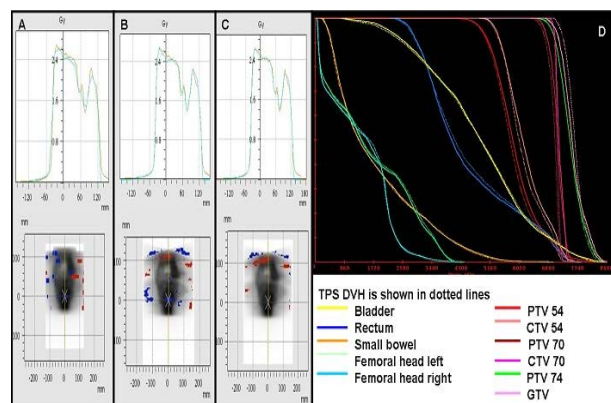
Results of a whole pelvis SIB treatment. In the upper part comparison of profiles for Octavius 4D (A), T-A EPID (B) and Transit EPID (C). In yellow the TPS profile. The lower part of the image contains central coronal map of gamma>1 points. In D the comparison of DVH measured by DC in plan CT (solid) versus TPS (dotted lines) is shown.
